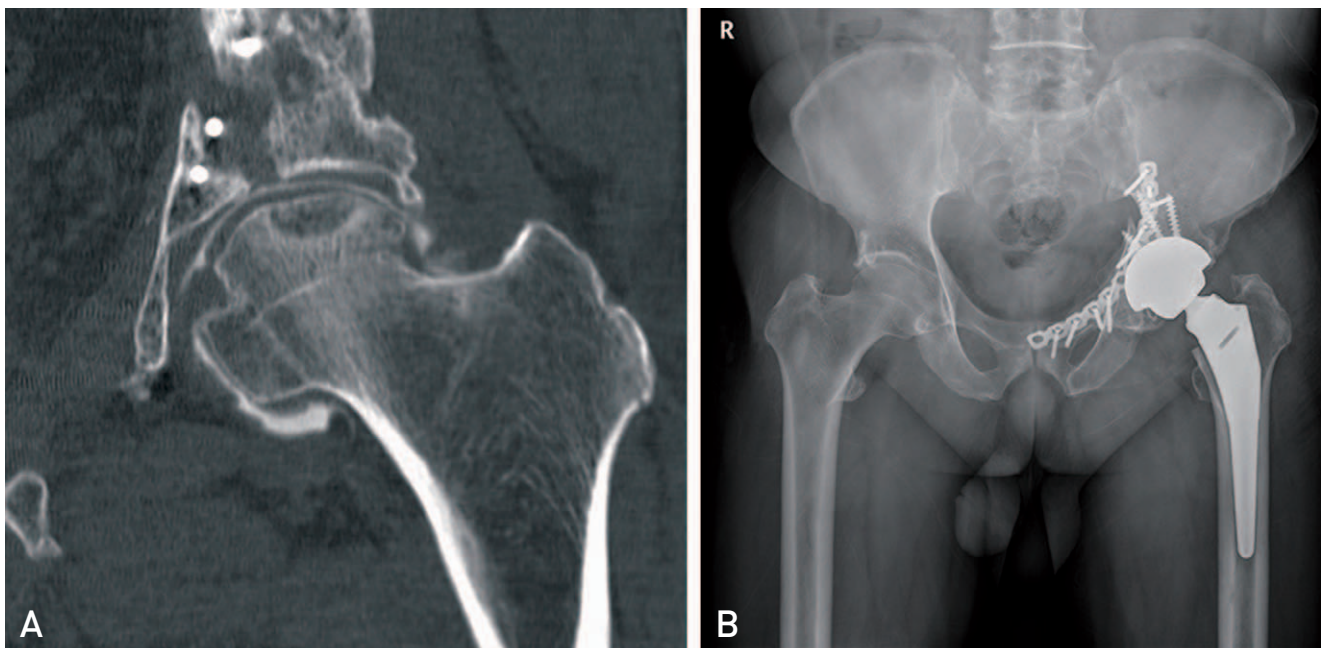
(A) Computed tomography scan showing osteonecrosis of the femoral head. (B) Postoperative x-ray image after total hip replacement.
